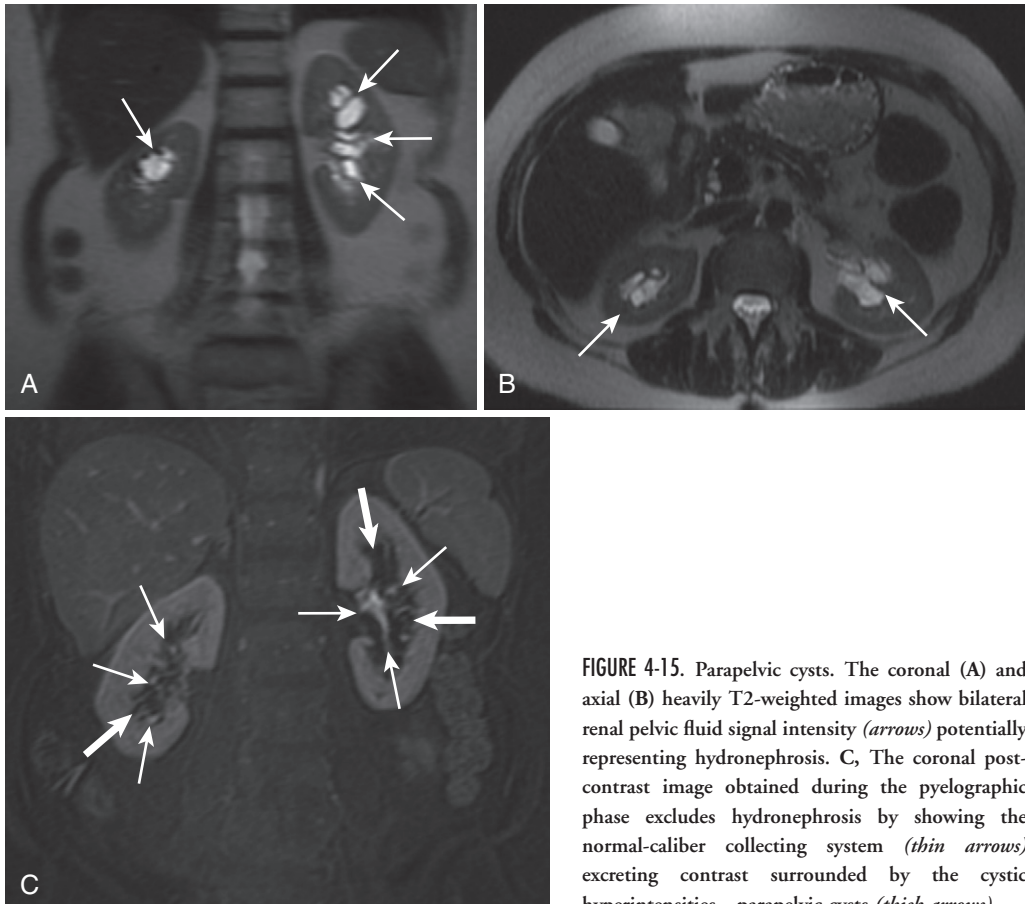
Parapelvic cysts. The coronal (A) and axial (B) heavily T2-weighted images show bilateral renal pelvic fluid signal intensity (arrows) potentially representing hydronephrosis. C, The coronal post-contrast image obtained during the pyelographic phase excludes hydronephrosis by showing the normal-caliber collecting system (thin arrows) excreting contrast surrounded by the cystic hyperintensities—parapelvic cysts (thick arrows).
